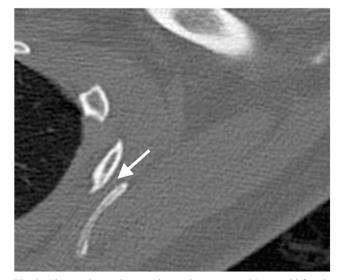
Abnormal scapular superior angle curvature. 25-year-old female with left scapular pain and crepitus. Axial CT of the left shoulder demonstrates narrowing of the distance between the superomedial scapula and third rib with mass effect on the serratus anterior muscle (arrow)
